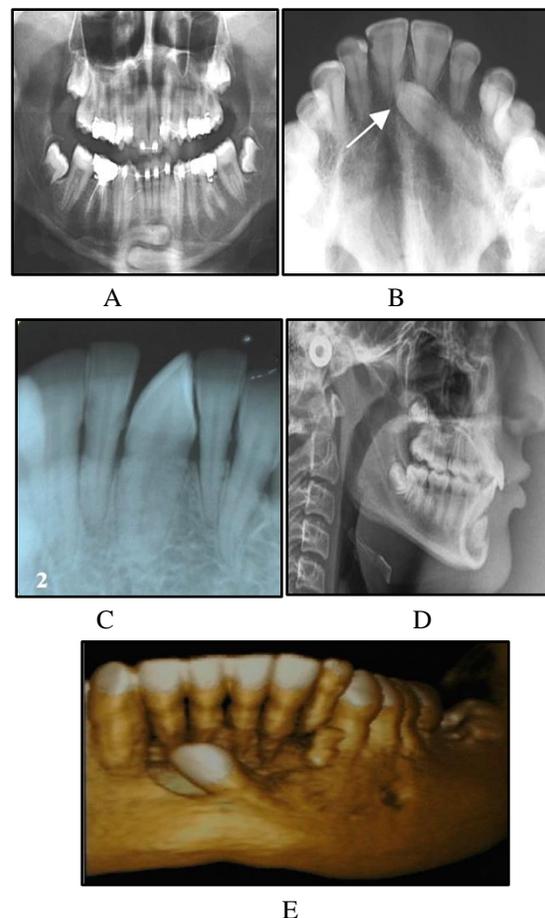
Investigation techniques (A) OPG (B) occlusal radiograph (C) IOPA (D) lateral cephalogram (E) CBCT 3-d reconstruction
